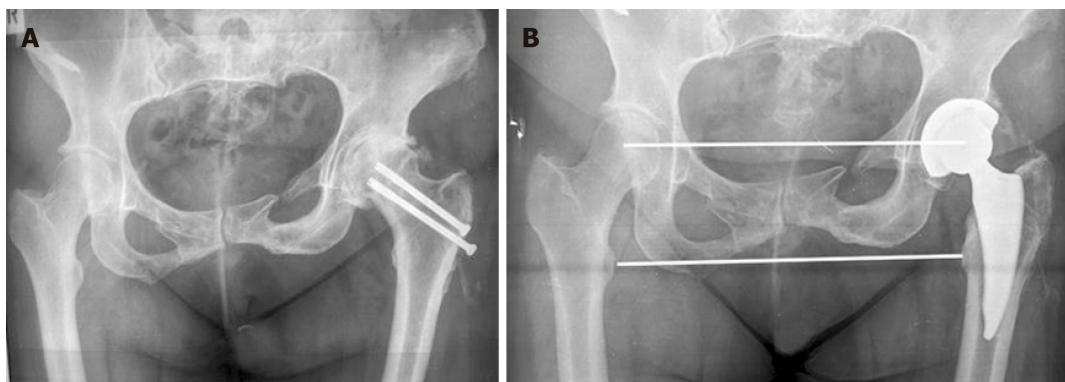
Ectopic ossification. A: Posttraumatic osteoarthritis; B: Radiographs at 4 years postoperatively.
